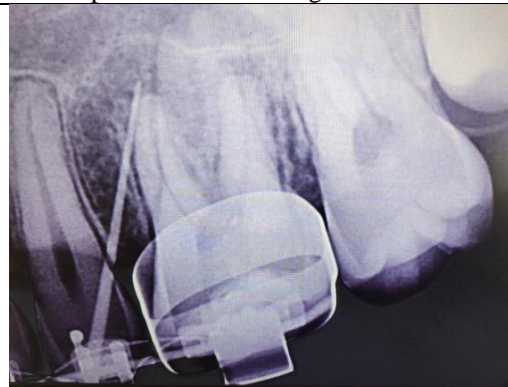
Radiograph after Sinus Tracking.
